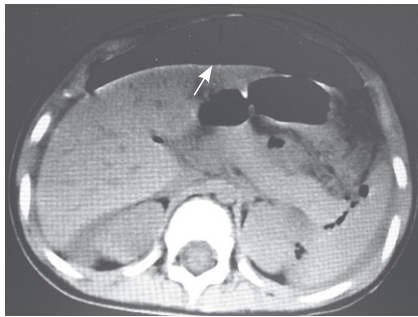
CT scan showing a massive gas shadow in the abdomen.
